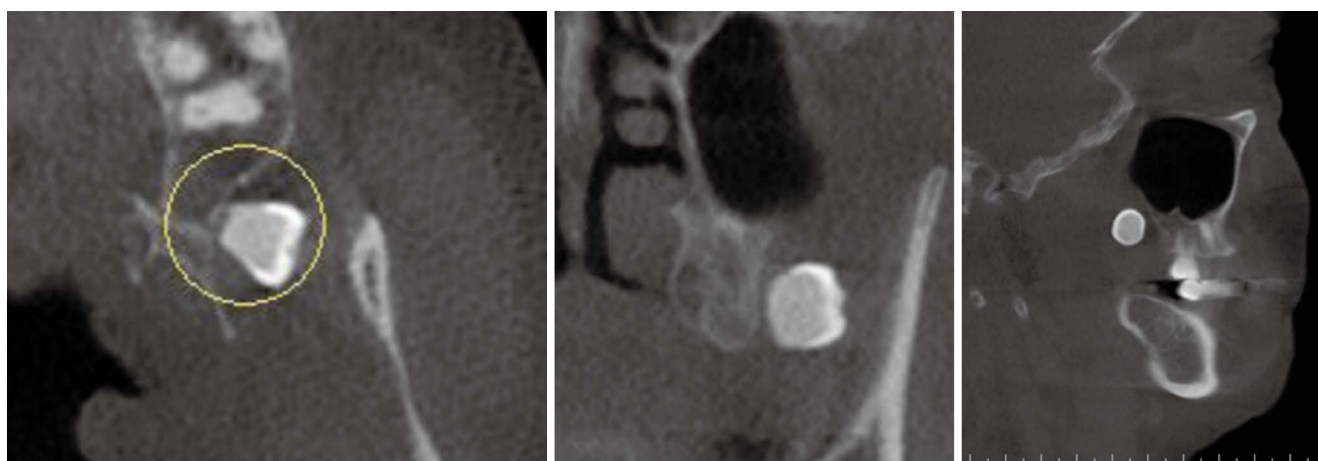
Axial, coronal, and sagittal cone-beam computed tomographic images depict an ectopic left maxillary third molar buccal to the maxillary tuberosity.
